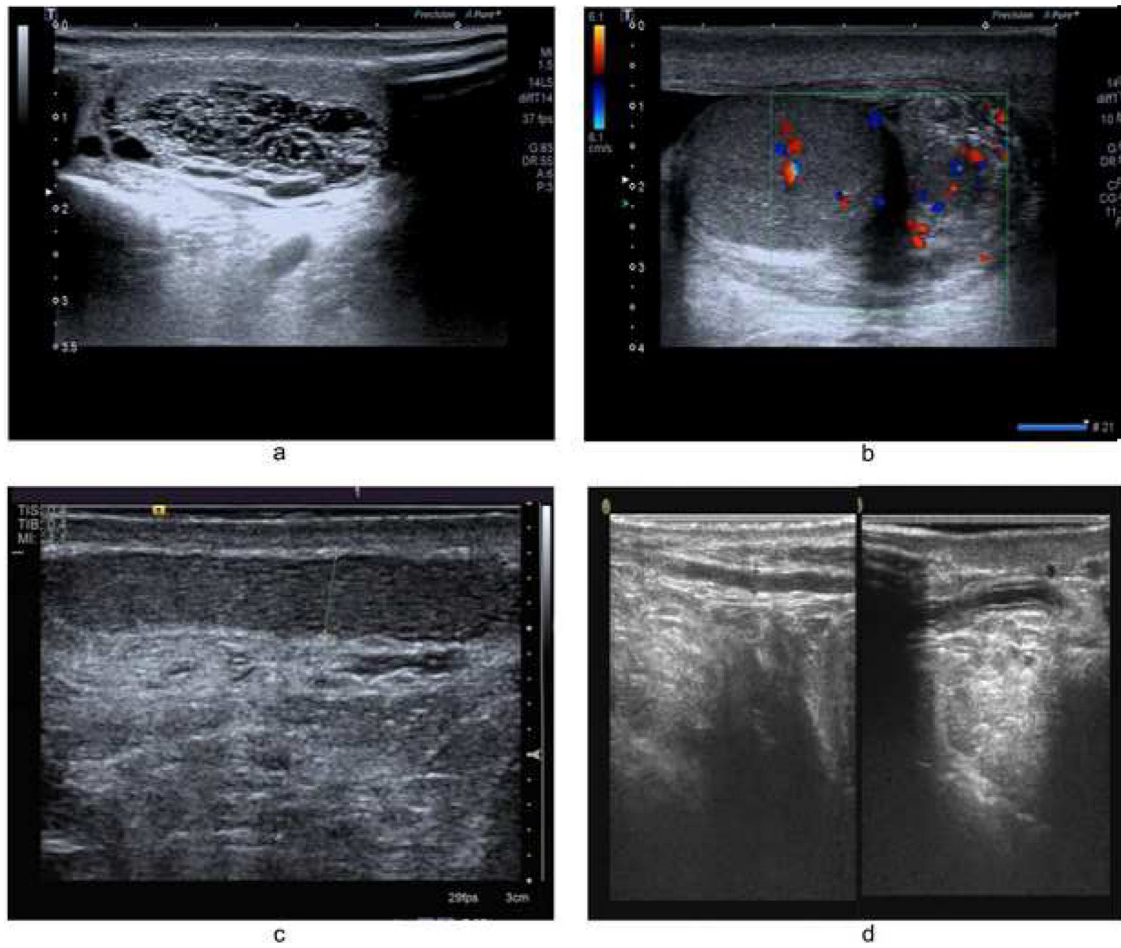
Scrotal ultrasound findings in acquired obstructive azoospermia, (a) expansion of the rete testis, (b) mass of epididymis tail, (c) thickening epididymis body with reticular change, (d) vas deferens dilation.
